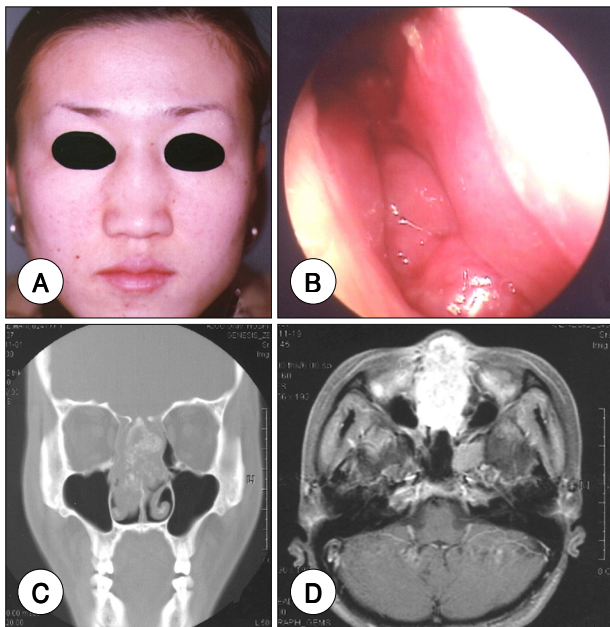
A : The patient face shows nasal dorsum widening and nasal bone thinning. B : Endoscopic findings show left septal hypertrophy and nasal obstruction due to masses. C : PNS CT (coronal view), space occupying mass with calcification in nasal septum was seen. D : PNS MRI (axial view, T1WI), nasal septal mass that has a low to intermediate signal intensity was seen. The mass extended to cribriform plate and lamina papyracea.
